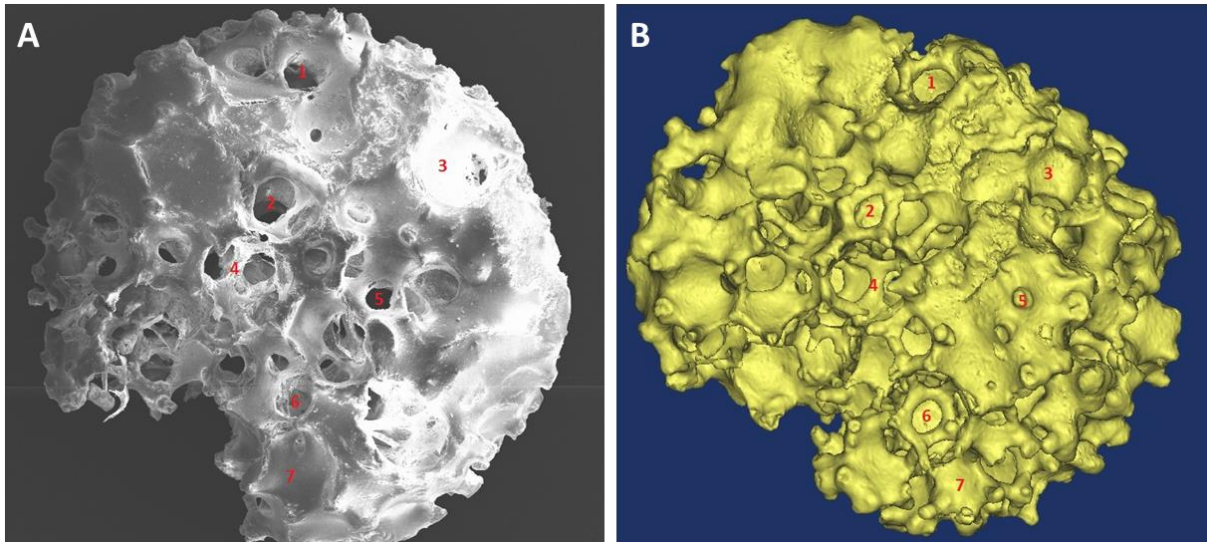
$\mu$ CT image and its corresponding 3D model of an implantable biomaterial scaffold. A)  $\mu$ CT image of an engineered bone construct with B), its corresponding 3D model.
